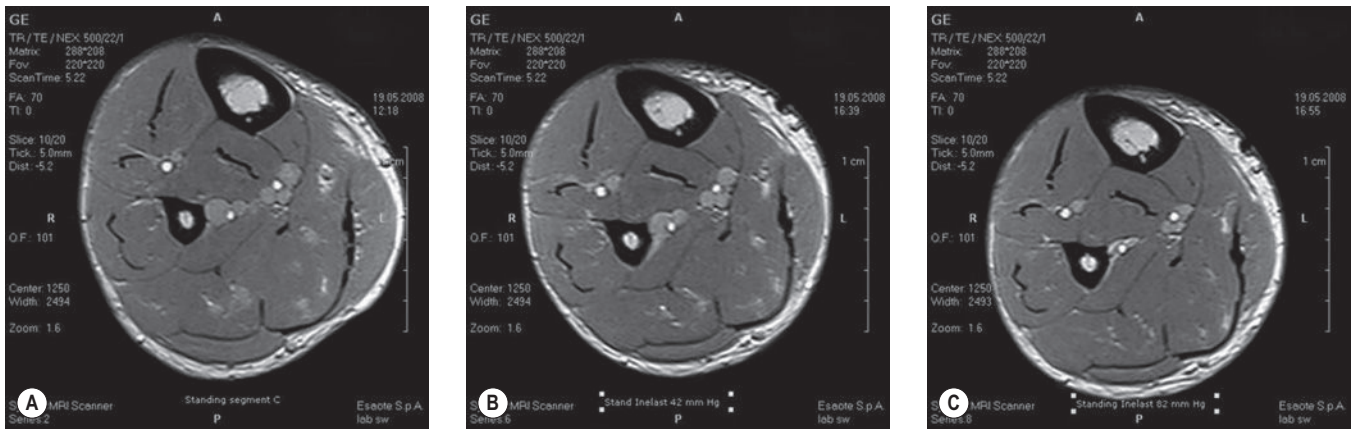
Magnetic resonance imaging of a crosssection through the largest calf segment in the standing position. A, Without compression; B, with a short-stretch bandage exerting a local pressure of 42 mmHg; C, with a pressure of 82 mmHg. A diameter reduction of the deep tibial posterior and peroneal veins can clearly be seen with increasing pressure. (Investigations together with G. Mosti at the laboratory of ESAOTE, Genova, Italy).
